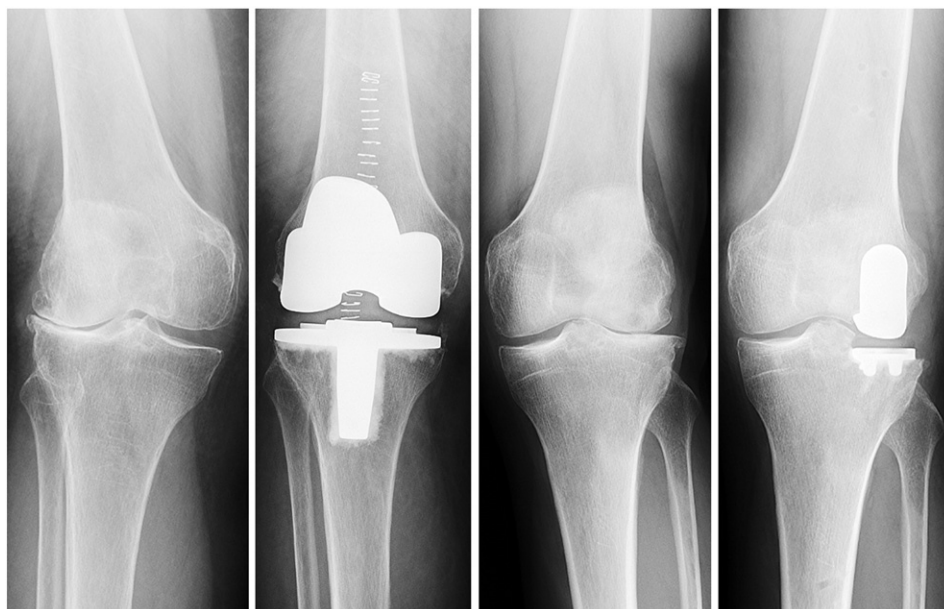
Pre- and postoperative radiographs are shown of two patients with isolated lateral osteoarthritis either treated with total knee arthroplasty (left) or unicompartmental knee arthroplasty (right).
